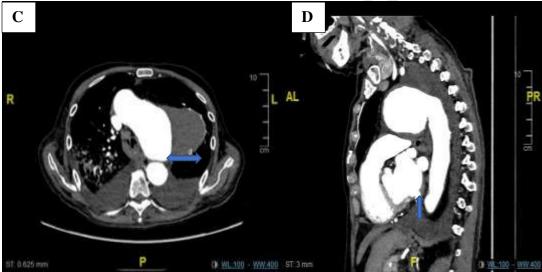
(A)Chest radiograph shows a widened mediastinum (black bidirectional arrow) with enlarged aortic knuckle (red arrow), displacing the trachea to the right (red arrow head). The right heart border is prominent (blue arrow) indicative of a dilated right atrium. There is bilateral pleural effusion. (B) Coronal section of CT angiogram of the thorax shows a large fusiform dilatation of the arch of aorta. (C) Axial section of the CT angiogram shows an aneurysm measuring 10.4cm in widest diameter with intramural haematoma measuring 4.9cm in thickness. (D) Sagittal section of the CT angiogram of the thorax shows that the aneurysmal dilatation is causing significant mass effect and compressing onto the main pulmonary artery (blue arrow).
